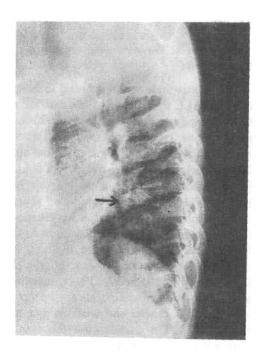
X-ray of the dorsolumbar spine showing collapse of D<sub>8</sub> vertebral body.
